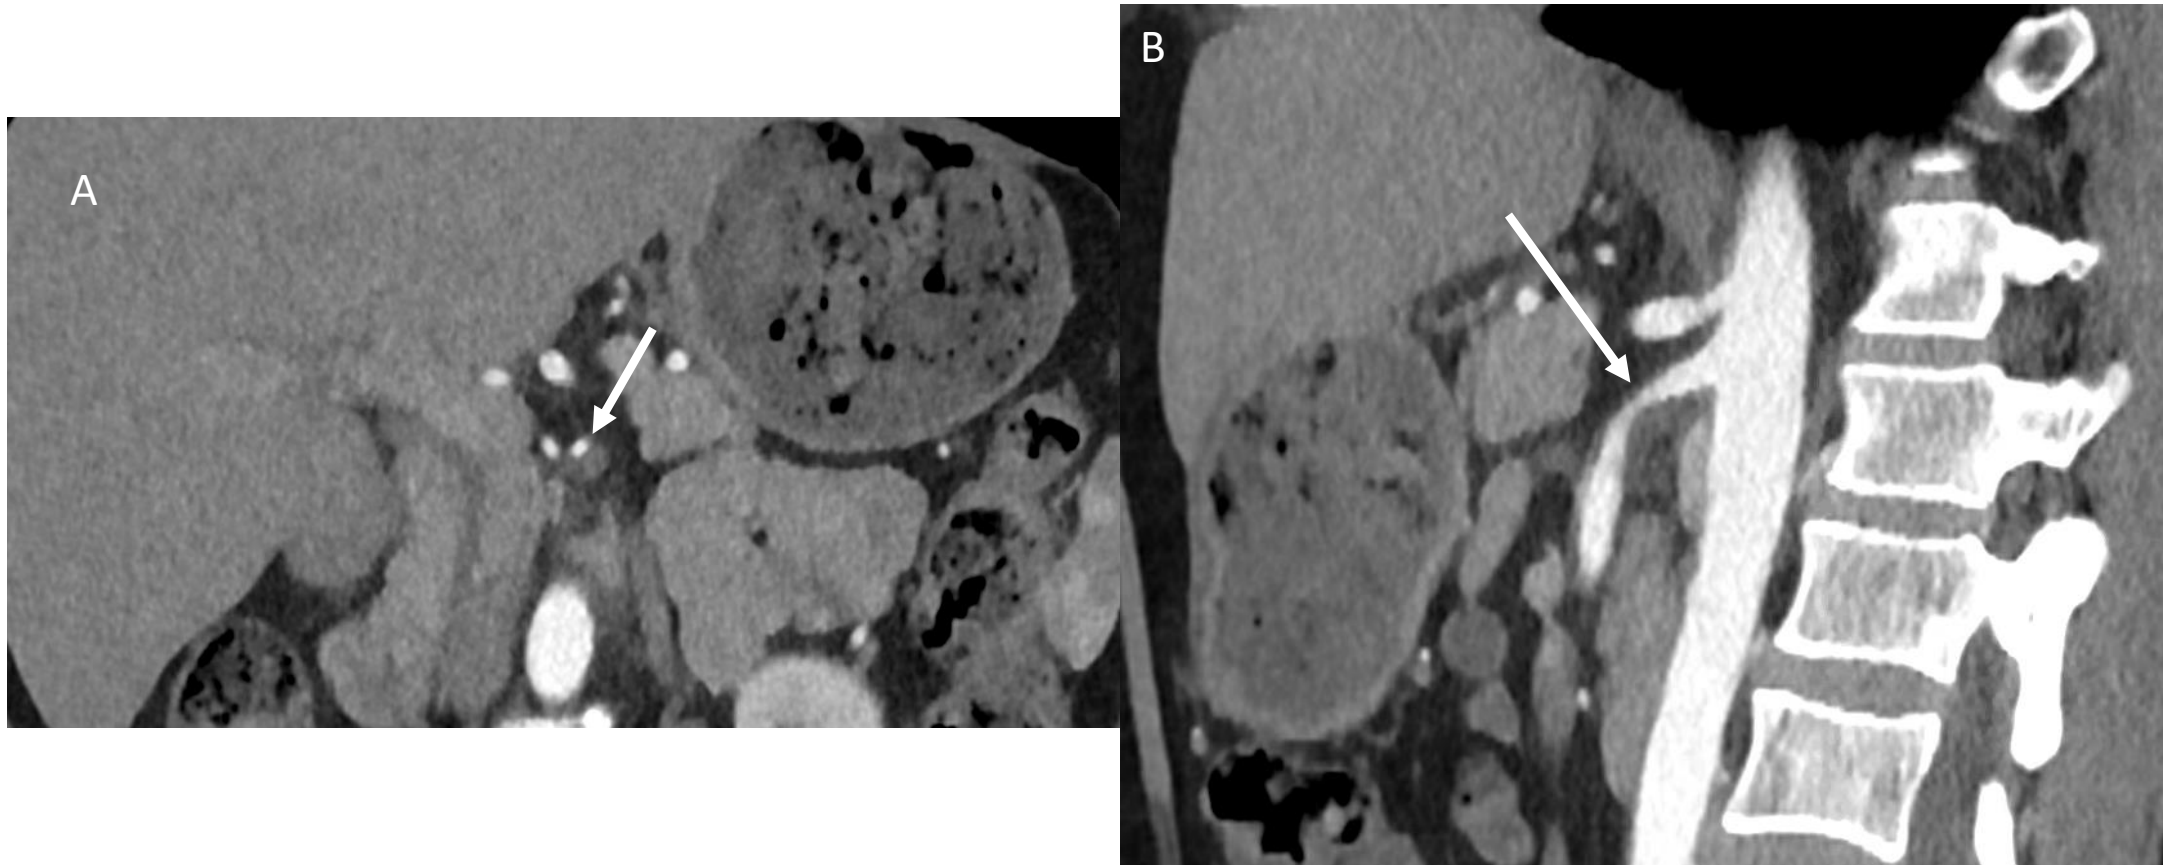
Abdominal CT-scan of a 87 years old patient with AMI showing an incomplete occlusion of the S2 segment of the SMA (arrow) : (A) axial view and (B) coronal view
